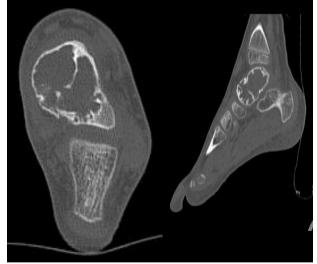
axial (a) and (b) sagittal images of computed tomography demonstrates septated, lobulated lytic lesion of the talus with significant thinning of the posterior cortex without signs of effraction neither periosteal reaction.
